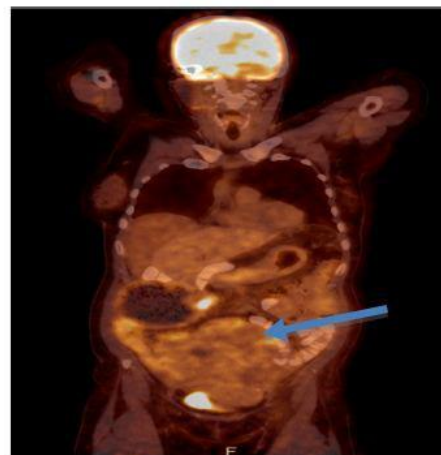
PET-CT 18-FDG heterogeneous hypercaptation of the pelvic tumor.
